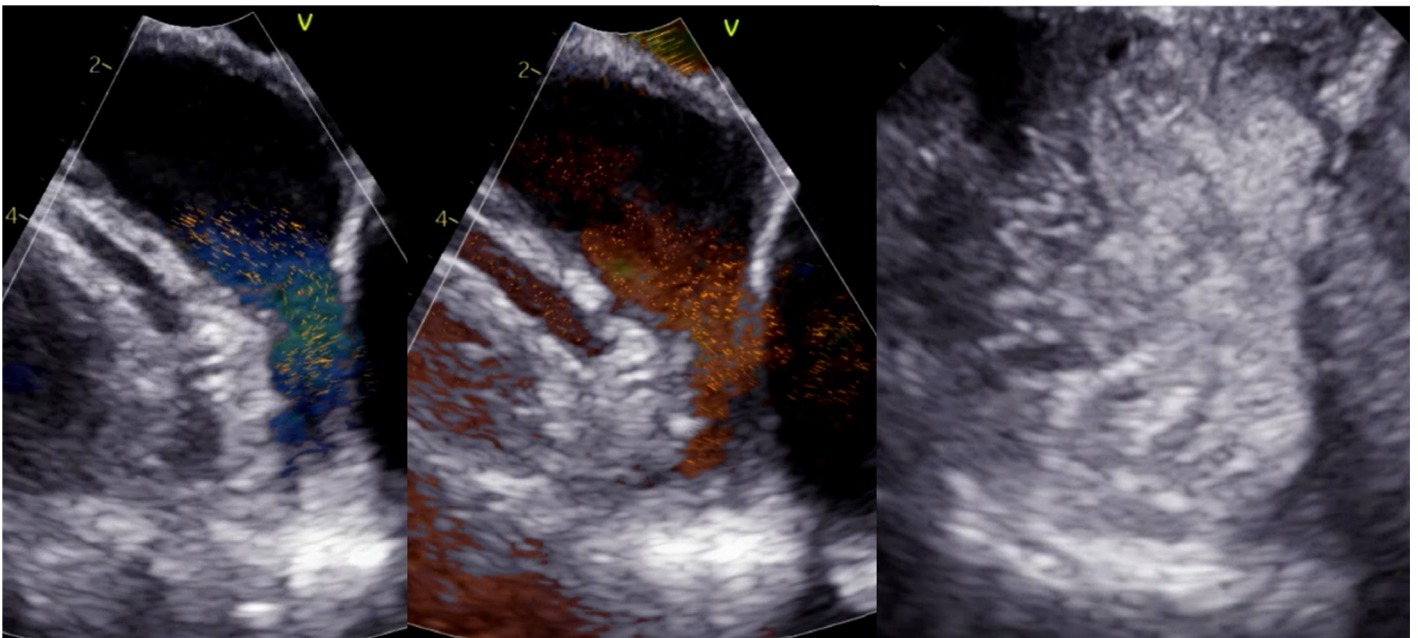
Entrance flow (i.e., filling) into the LAA (left) and emptying flow during LAA contraction (center) is shown with BSI with color Doppler overlay in a patient with dense spontaneous echo contrast. Moving blood speckles are seen throughout the appendage suggesting absence of LAA thrombus. Ultrasound enhancing agent administration with low mechanical index imaging of the LAA was also performed demonstrating penetration of contrast into the entire LAA confirming the absence of thrombus (right). LAA=left atrial appendage.
